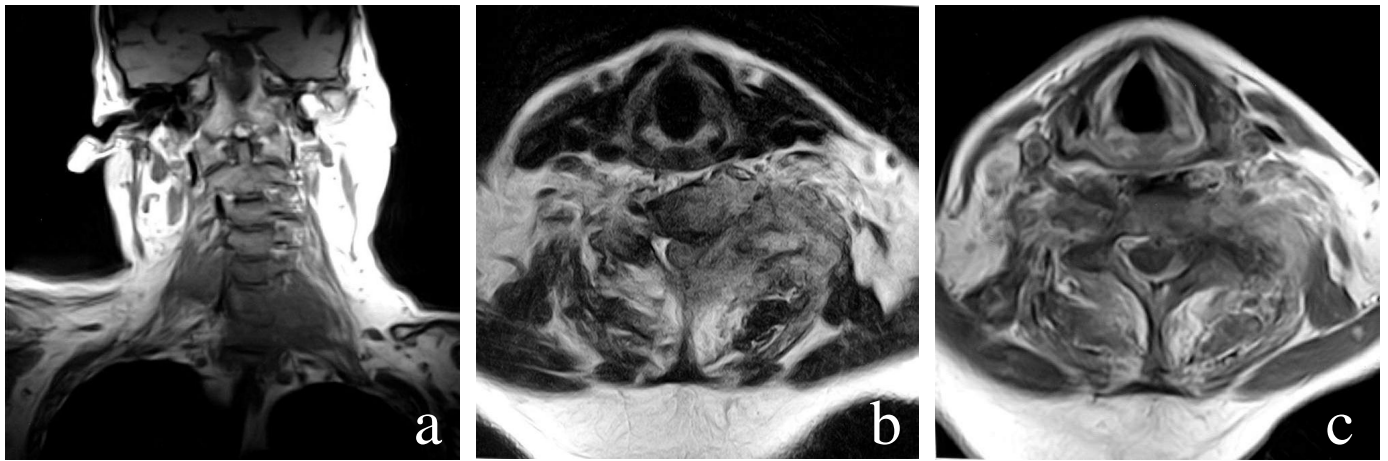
T1-weighted SE (TR/TE, 650/15) coronal (a) and T2-weighted TSE (TR/TE, 3590/100) axial (b) images show bilateral metastatic masses on the brachial plexus which invades the C5-C7 vertebrae. The neural foramina, and marked heterogeneous enhancement is seen on postcontrast T1-weighted SE (TR/TE, 650/15) axial image (c).
